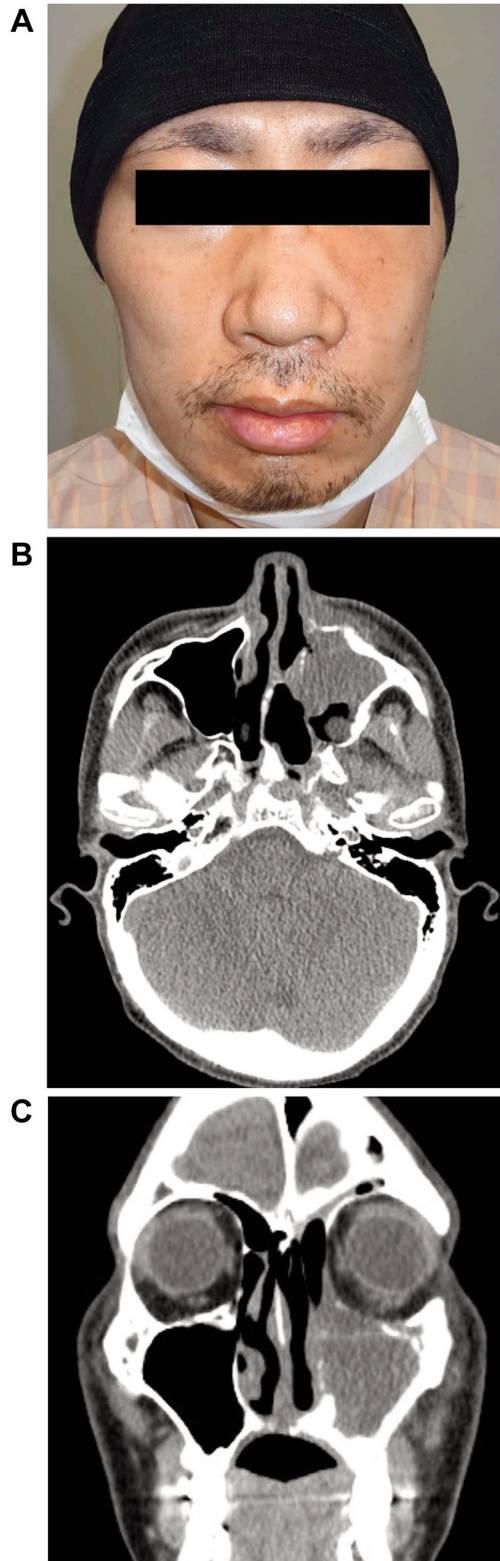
Evaluation after three courses of docetaxel, cisplatin, and 5-fluorouracil. A: The left ocular deviation had improved. B and C: Sinus computed tomography showed shrinkage of the tumor in the left maxillary sinus (axial and coronal planes, respectively).
